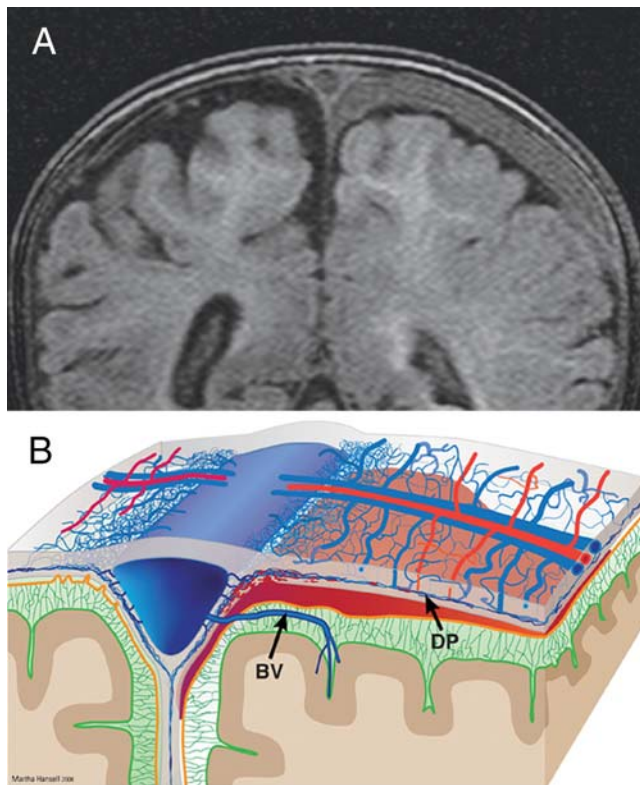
Left subdural compartment hemorrhage. a T1-W coronal MR image shows left subdural compartment hemorrhage. b Graphic representation of hemorrhage originating from the inner dural plexus (*BV* bridging vein, *DP* dural plexus)
